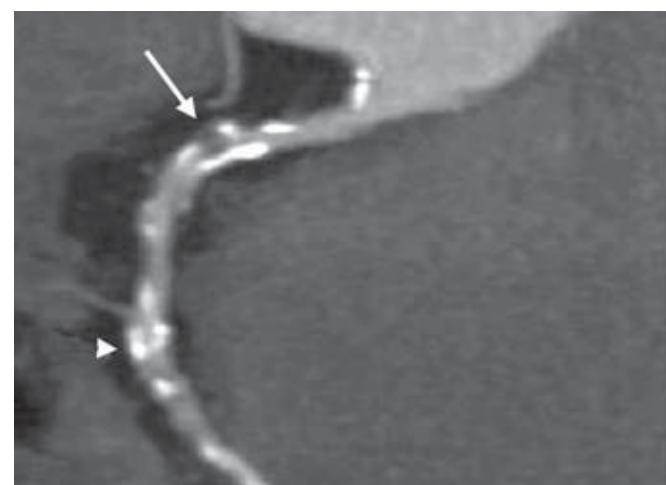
Image of coronary computed tomography-angiography showing calcified plaques in right coronary artery.³²
